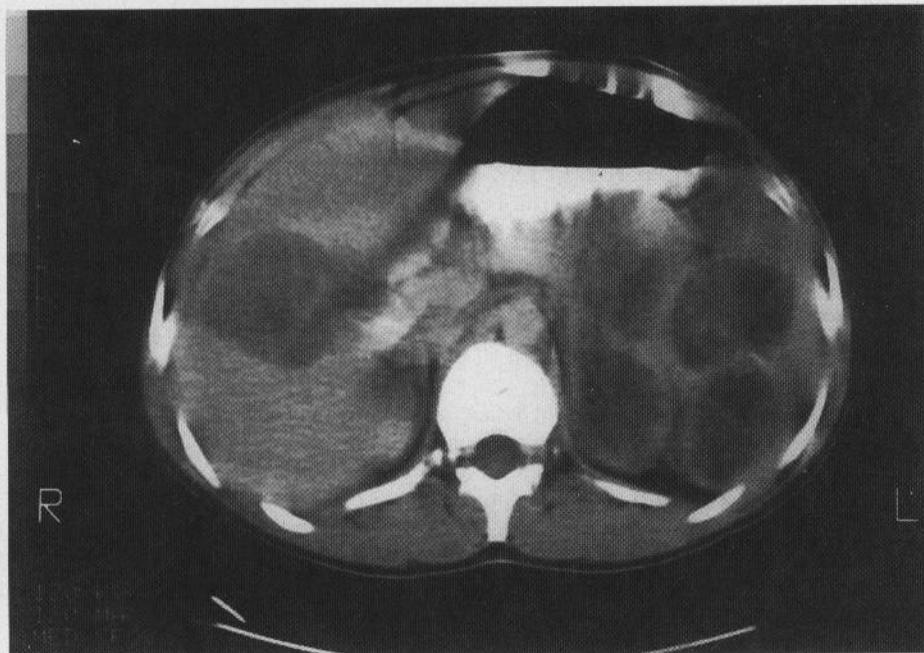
CT scan showing hydatid cysts in the liver and left kidney.
